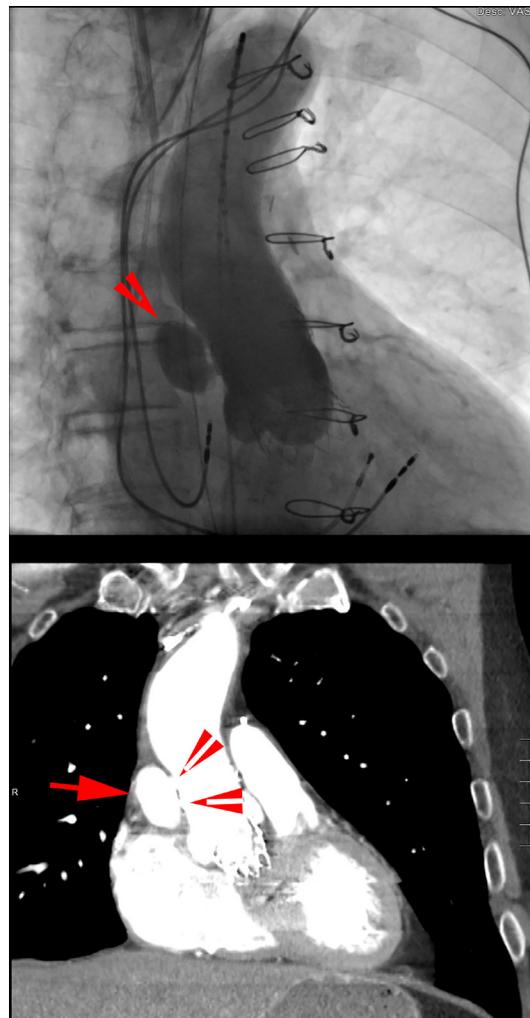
Top panel: pre-procedure aortography demonstrating pseudoaneurysm in communication with ascending aorta just distal to the transcatheter aortic valve repair scaffold (arrowhead). Bottom panel: pre-procedure CT scan demonstrating pseudoaneurysm (arrow) with two necks (arrowheads) communicating with ascending aorta.
